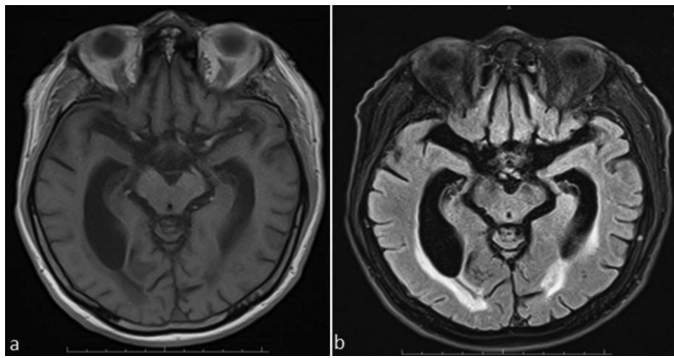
T1-weighted and fluid-attenuated inversion recovery brain magnetic resonance imaging were consistent with cortical atrophy and chronic gliotic changes
